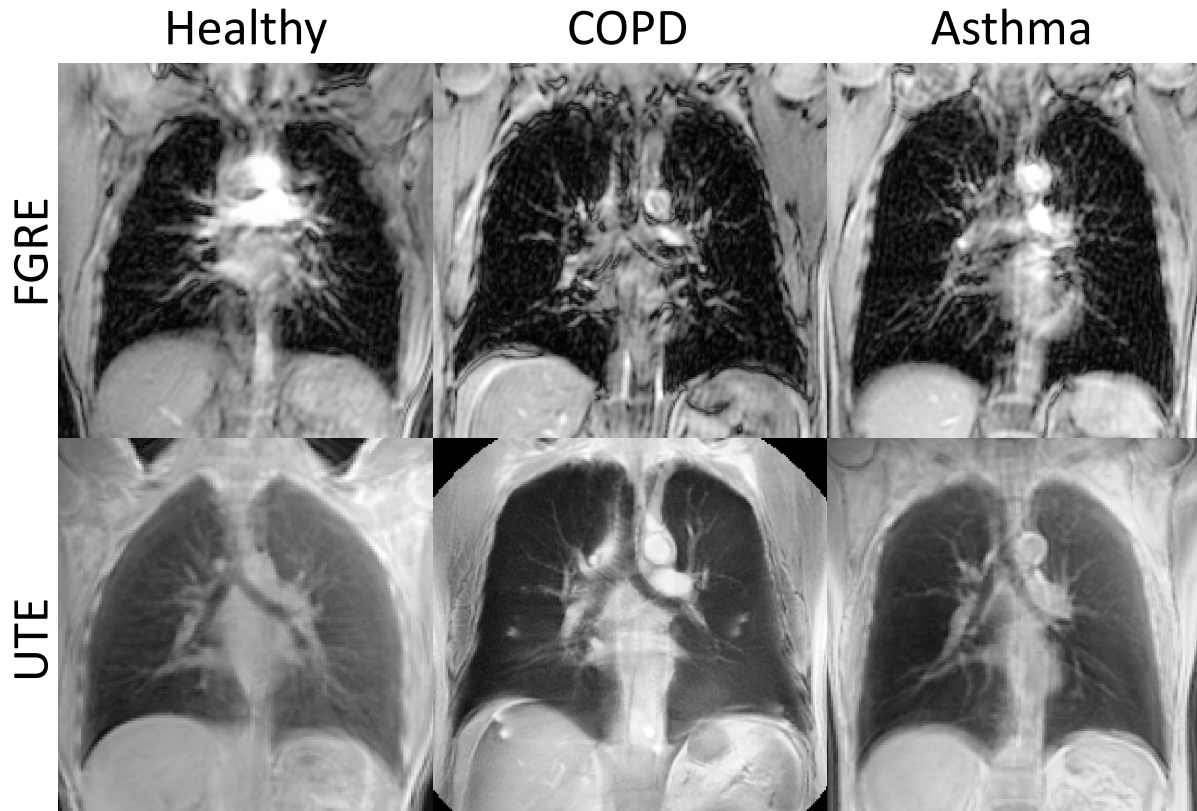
Representative conventional FGRE and UTE MR coronal images of a healthy, COPD and asthma subject. In conventional FGRE MRI, lung structural abnormalities inherent to obstructive lung disease cannot be visually distinguished due to low tissue and  $^1\text{H}$  density. In contrast, UTE MRI provides enhanced visualization of the lung with higher signal intensities and regions of low signal intensities are visible in obstructive lung disease compared to the healthy volunteer.
